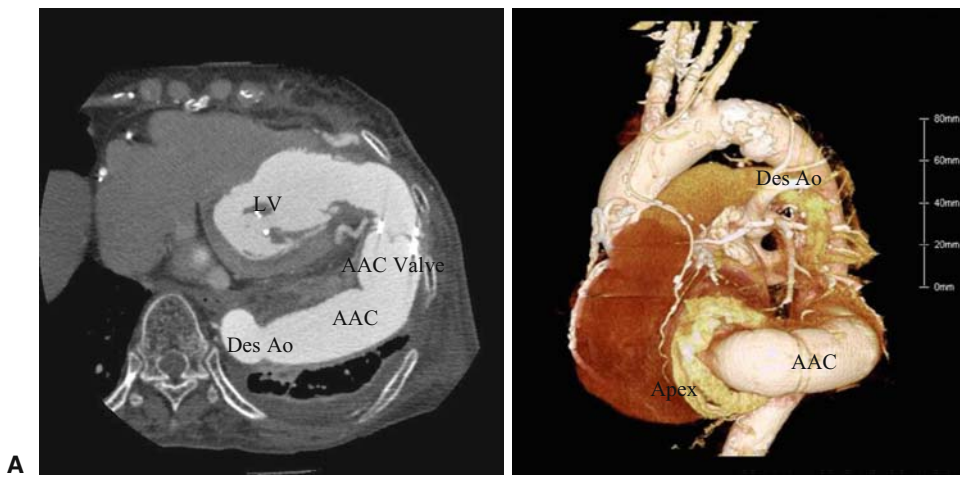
Postoperative computed tomography (CT) images from case 1 showing no compression or stenosis in the AAC. A Enhanced CT. B Three-dimensional (3D)-CT. *LV*, Left ventricle; *AAC*, apicoaortic conduit; *Apex*, apex of heart; *Des Ao*, descending aorta
